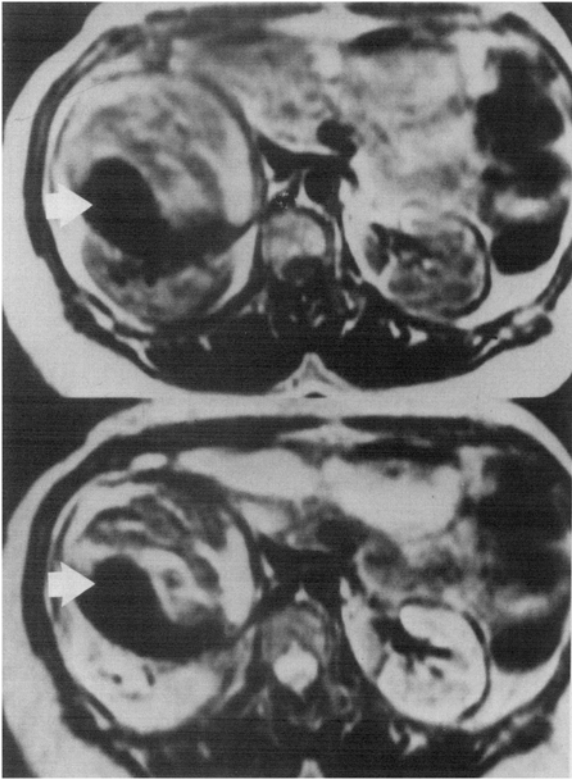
Case 1. T1- and T2-weighted magnetic resonance images show signal void within the patent lumen of the aneurysm (*thick arrows*).
